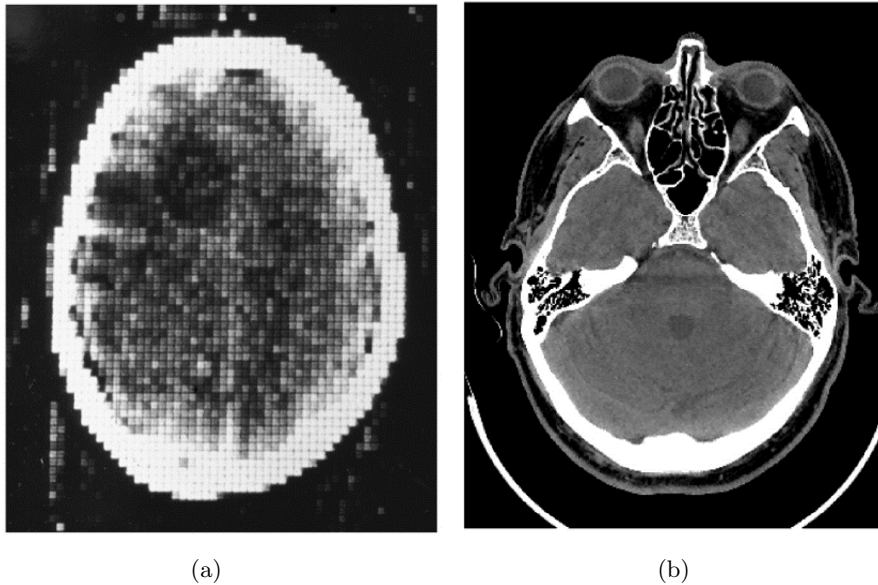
Comparison between (a) an image obtained with the first CT scanner and (b) an image obtained with an up-to-date CT scanner (adapted from (Hsieh, 2009))
